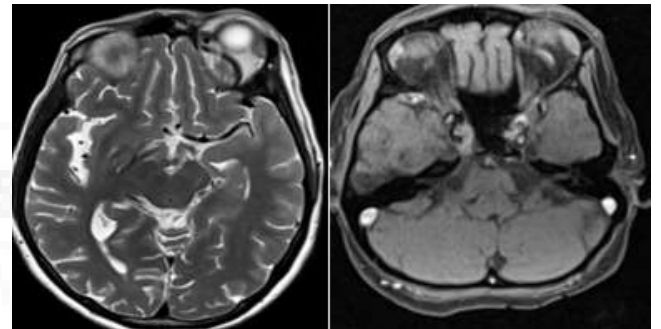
MRI Orbit show prominent cavernous part of the bilateral internal carotid artery and left superior ophthalmic vein consistent with carotico-cavernous fistula.
